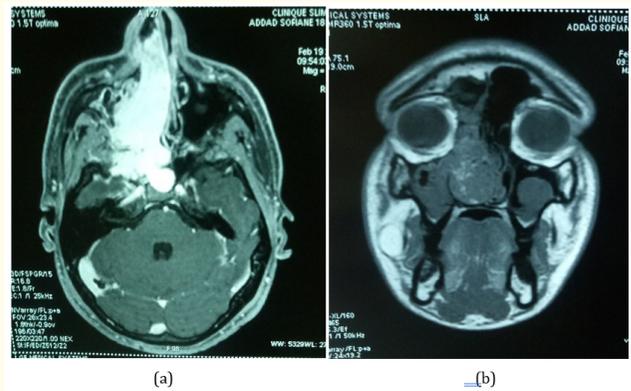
Preprocedural MRI axial (a) and coronal (b) views showing large right nasopharyngeal mass (Hyper signal in T2 weighted, intermediate signal in T1 weighted) pushing medially the septal cartilage, and the lateral wall of maxillary sinus with expansion to the sphenoid sinus posteriorly and right infratemporal fossa, without intracranial or skull base invasion, the tumor is classified IIc according to Radkowski stage.
